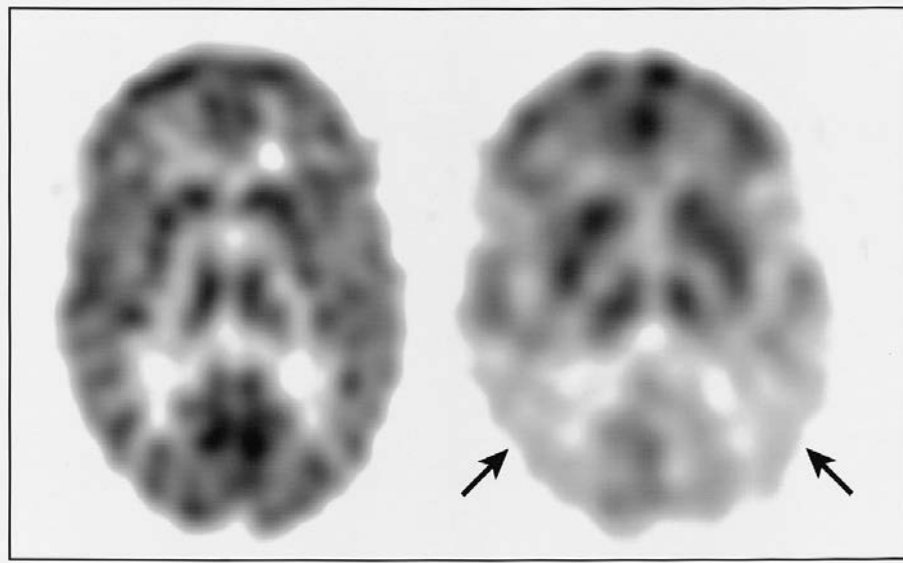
Comparison of cerebral glucose metabolism, measured using ^{18}F FDG and PET, in a normal healthy subject (*left*) and a patient with Alzheimer's disease (*right*). The pattern of hypometabolism reflects neuronal degeneration in the temporoparietal regions (arrows), which is consistently found in AD. (Images courtesy of Dr David Mozley, University of Pennsylvania.)
